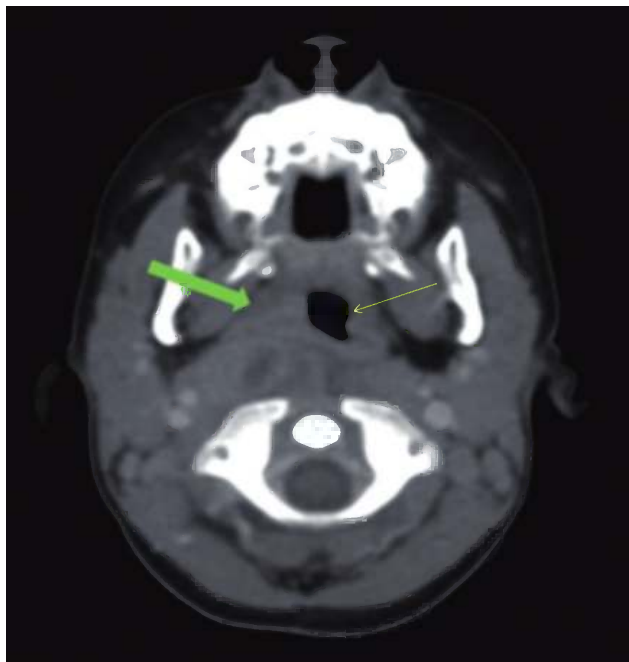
CT scan revealing a retropharyngeal abscess, with the green arrow pointing to the abscess and the yellow arrow pointing to the airway.
